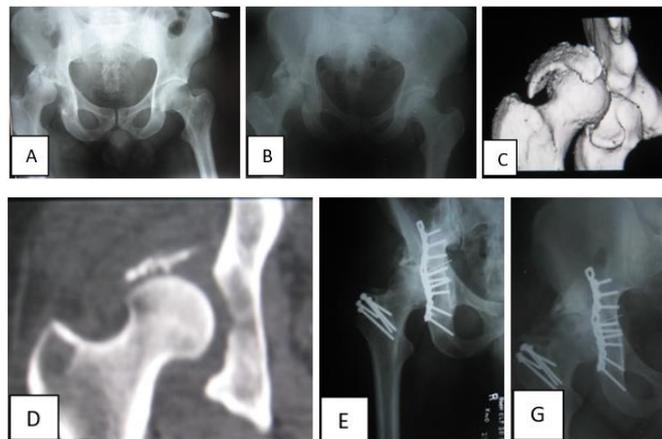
A: X ray pelvis with both hips in a 36 yr old male – shows fracture dislocation of right hip mainly involving posteriosuperior wall. B: He underwent emergency reduction of right hip. Post reduction x ray shows subluxation. C, D: CT scan shows posterior superior wall fracture with subluxation. E: Treated by ORIF posterior wall through Kocherlangenbeck approach with trochanteric flip extension. F: Follow up x ray shows features of Myositis ossificans.
